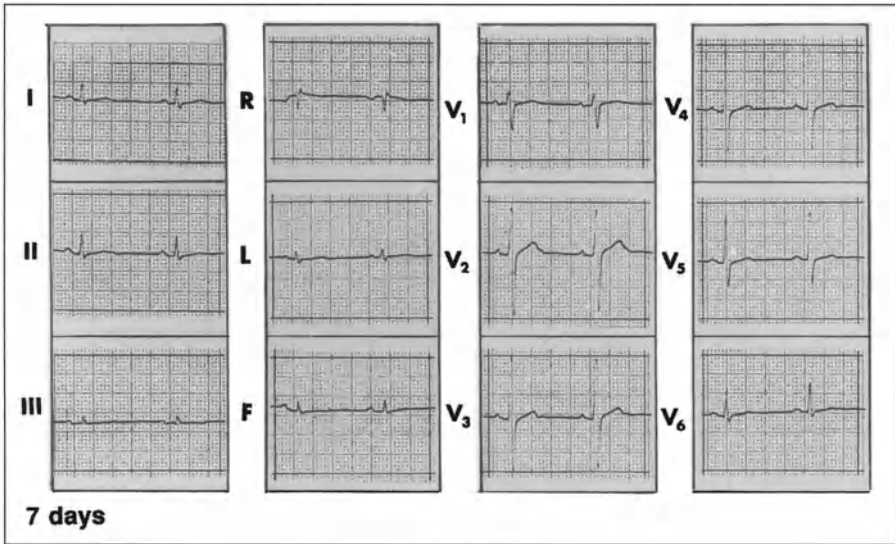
A complete normalization of repolarization appeared only after 7 days. In this patient a successive exercise test, myocardial scintigraphy and coronary angiography failed to demonstrate the presence of ischemic disease
